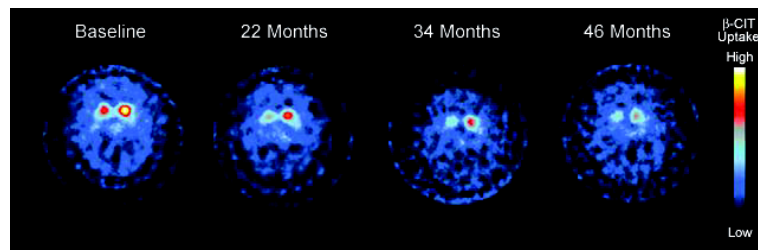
^{123}I - β -CIT SPECT images show progressive decline of nigro-striatal DAT function in patients with Parkinson's disease (PD). Replicated with permission.
